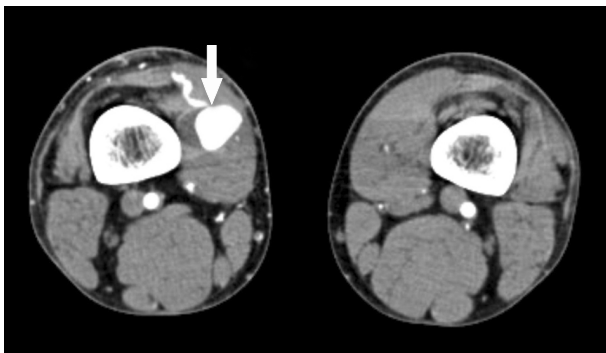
Transverse view of computed tomography angiography showing a pseudoaneurysm and fistula of the superficial vein (solid arrow).
